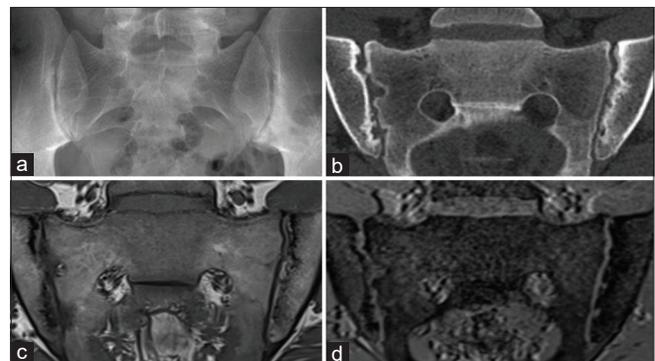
Images of a 27-year-old male with erosions in both sacroiliac joints. With reference to computed tomography (b), erosions are better depicted on three-dimensional volume-interpolated breath-hold examination images (d) than on T1-weighted magnetic resonance images (c) and on the radiograph (a)
